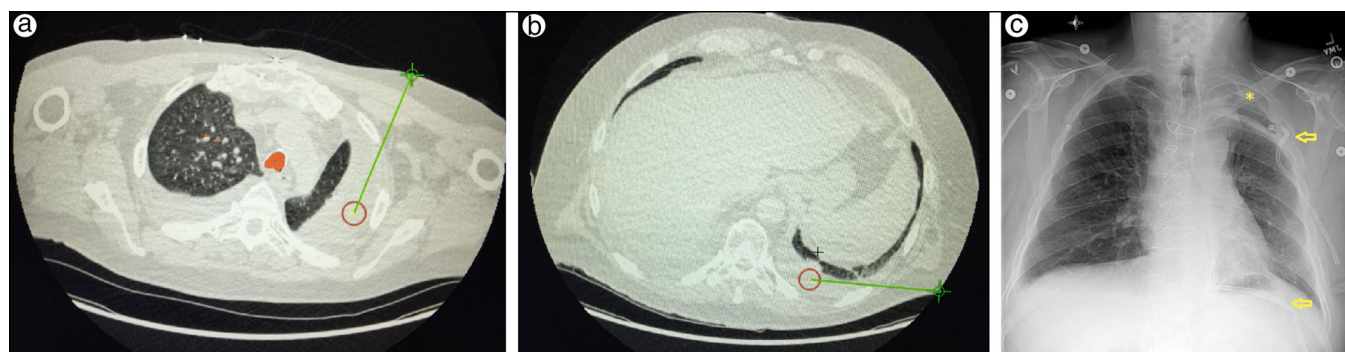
Electromagnetic navigation plan for thoracostomy tube placement of (a) left apical and (b) basal loculated effusions. (c) Chest x-ray showing successful placement of left apical and basal thoracostomy tubes (arrows) and left apical pneumothorax from trapped lung (*).
